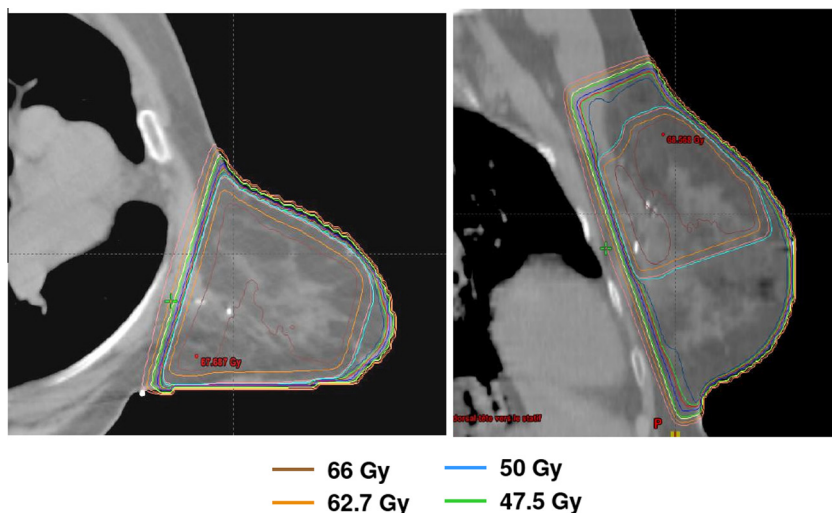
Axial and sagittal CT scan images showing the dosimetry of whole breast radiotherapy and boost to the tumor bed delivered in lateral position. The colors of isodoses 95% and 100% are given.
